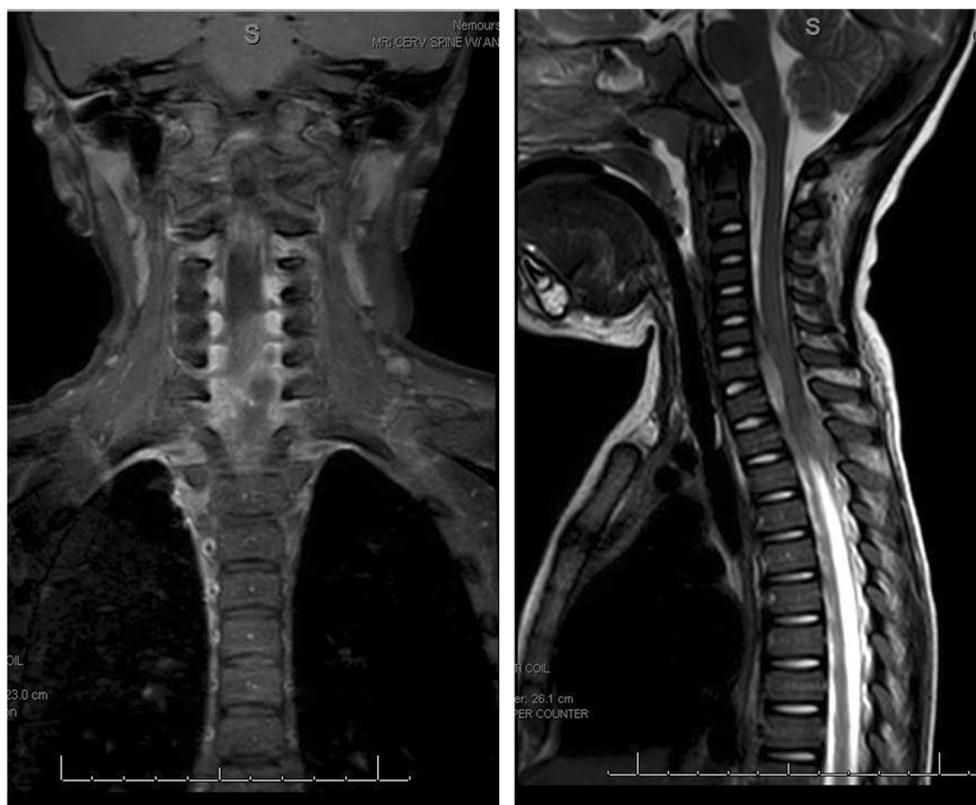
and 2 MRI of cervical spine. Interpretation: Extensive paraspinal edema involving the cervical and upper thoracic spine with the epicenter in the region of the transverse process/facet joint and pedicle of T2 on the right. There is some slight widening of the right neural foramen from T1
